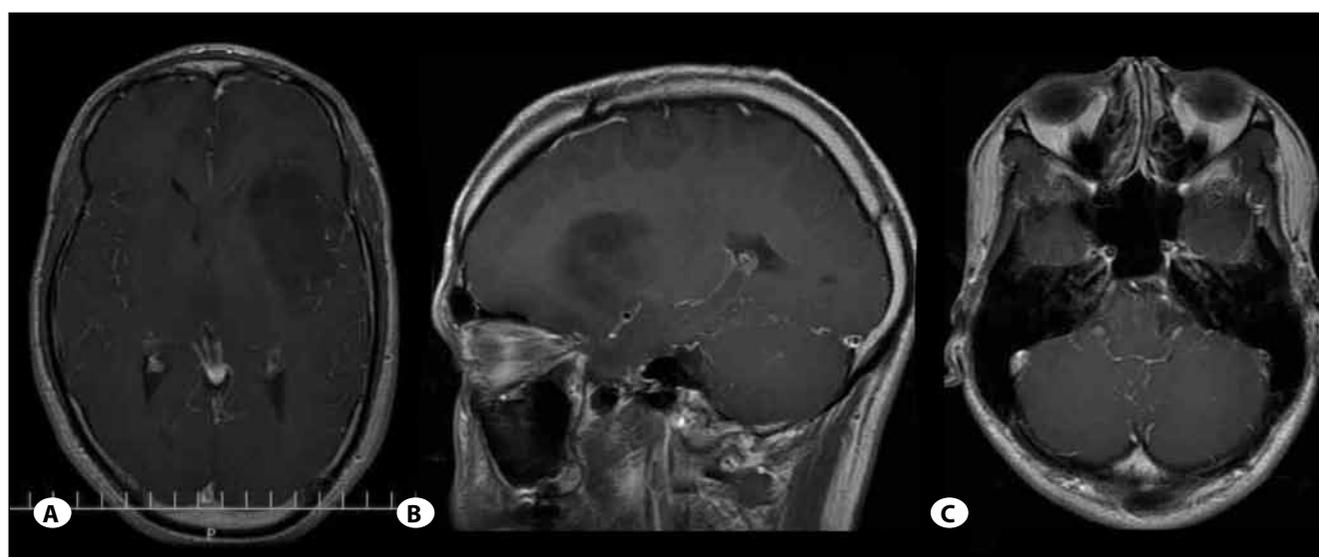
A gadolinium (Gd)-enhanced (A) axial and (B) sagittal T1-weighted magnetic resonance imaging (MRI) portrayal shows a slightly enhanced mass lesion in the left insula region. (C) There was no mass in the posterior fossa at the initial surgery.
